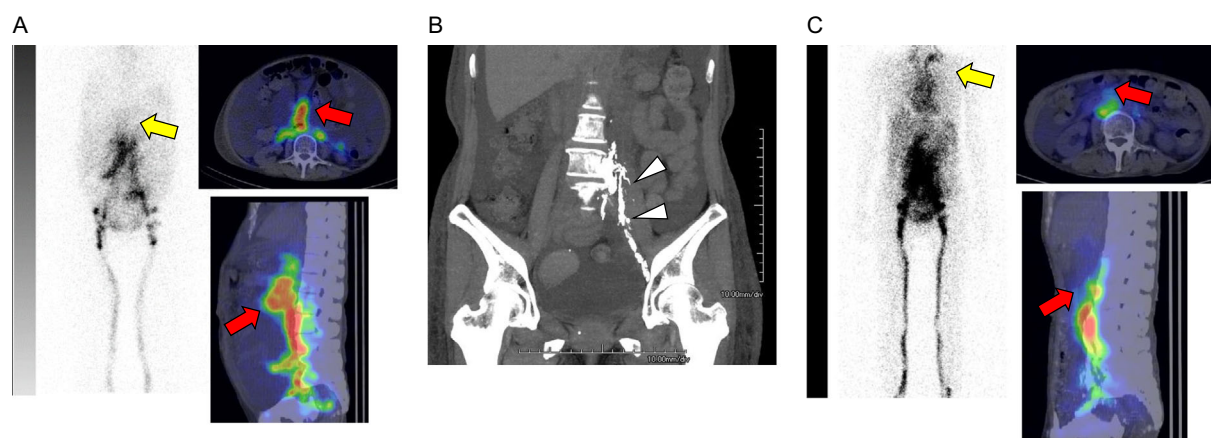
(A) Lymphatic scintigraphy after 3 courses of chemotherapy, before lymphangiography with Lipiodol. Before lymphangiography with Lipiodol, the lymphatic flow leaked into the abdominal cavity (red arrows) and was disrupted at the renal hilum level (yellow arrow). (B) Lymphangiography with Lipiodol. The dilated lymphatic vessels were contrasted by Lipiodol administered from the left inguinal lymphatic vessel (arrowheads). (C) Lymphatic scintigraphy after lymphangiography with Lipiodol. After 3 weeks of lymphangiography, leakage into the abdominal cavity was stopped (red arrows), and the lymphatic flow reached the left subclavian venous angle (yellow arrow).
